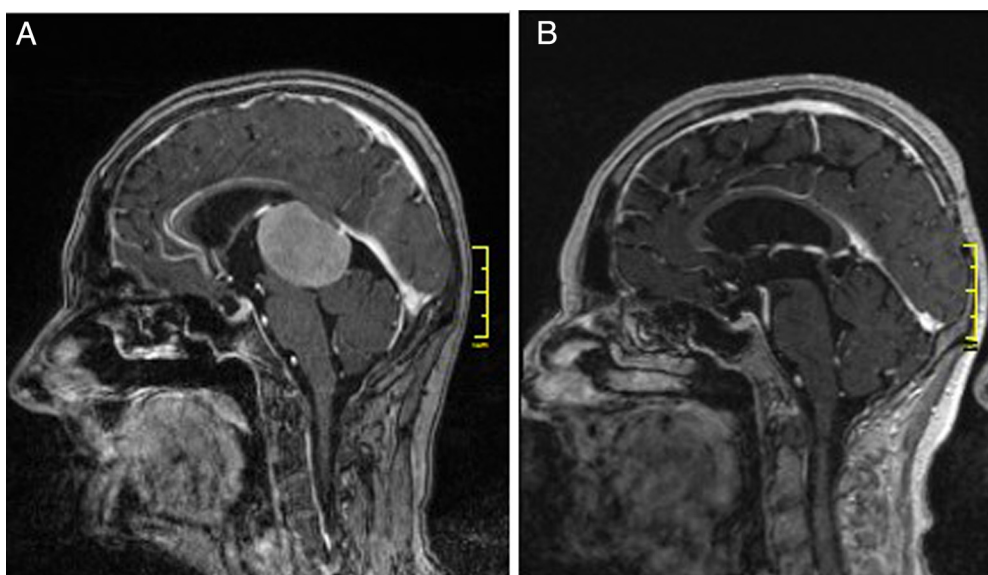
(A) Preoperative sagittal T1 contrast enhanced MR image demonstrating velum interpositum meningioma. (B) Postoperative sagittal T1 contrast enhanced MR image obtained after complete resection of the tumor.
